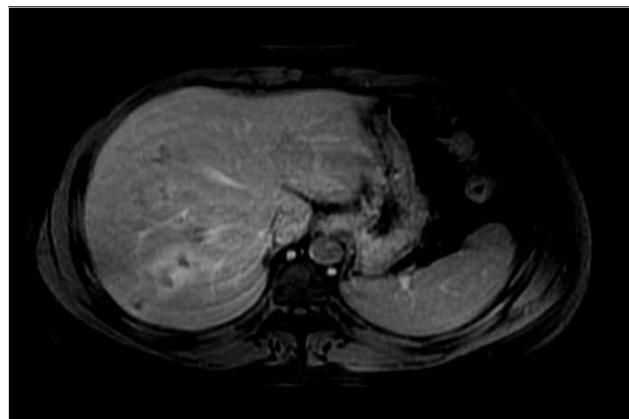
On axial T1 C+ MR images, multiple clustered nodular lesions are observed in the posterior segment of the right lobe, and hypointense lesions with peripheral contrast enhancement are observed in the liver
